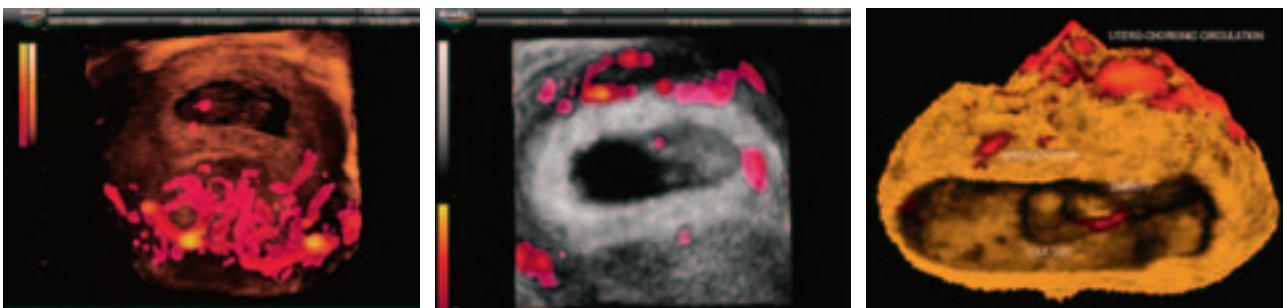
3 dimensional image of the developing intervillous circulation in the maternal site of placenta at fifth week of gestation. Doppler shows intense vascular activity surrounding the chorionic shell.
